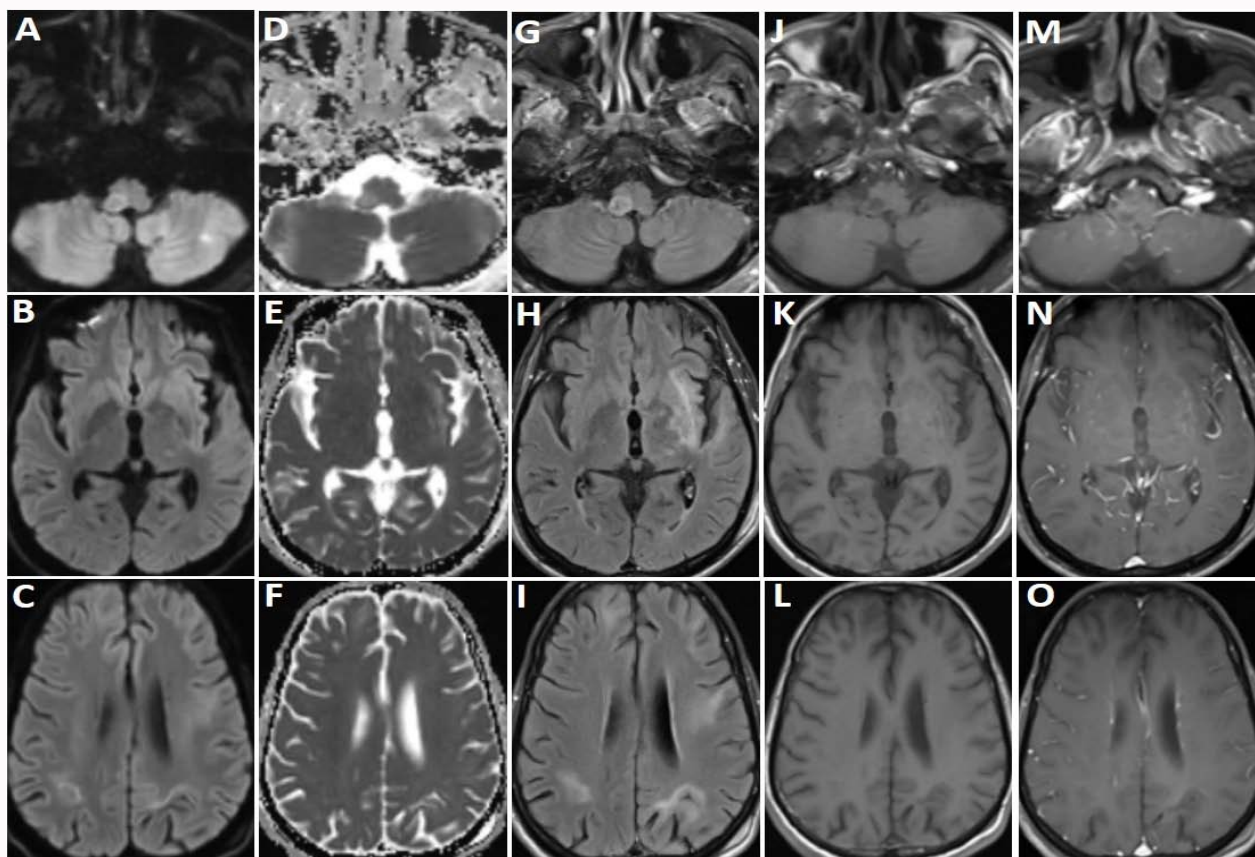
MRI brain during second admission. Axial images (A, B, C- DWI; D, E, F- ADC; G, H, I- T2 FLAIR; J, K, L- T1W pre-contrast and M, N, O- T1W post-contrast sequences) showed expansion of right medullary lesion with peripheral diffusion restriction and FLAIR hyperintensity with new frontal white matter hyperintensities, involving subcortical U fibers with a sharply demarcated peripheral border and an ill-defined inner border. None of the lesions showed any contrast enhancement.
